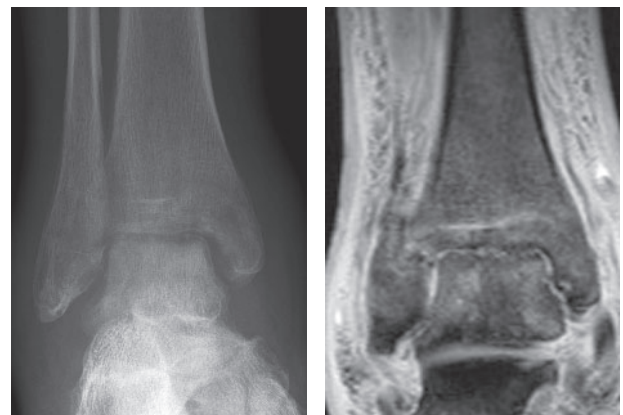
MRI A case of septic arthritis of the ankle, suspected from the plain X-ray (a) and confirmed by MRI (b).
